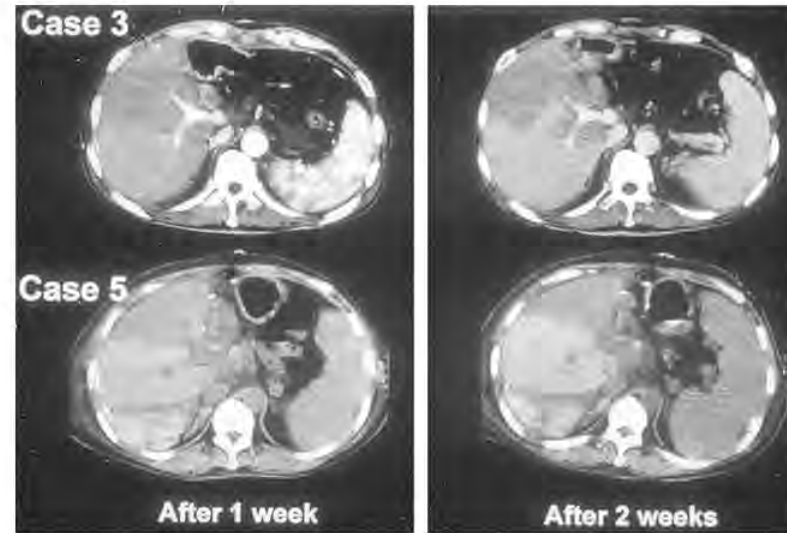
Postoperative computed tomography in patients 3 and 5.
